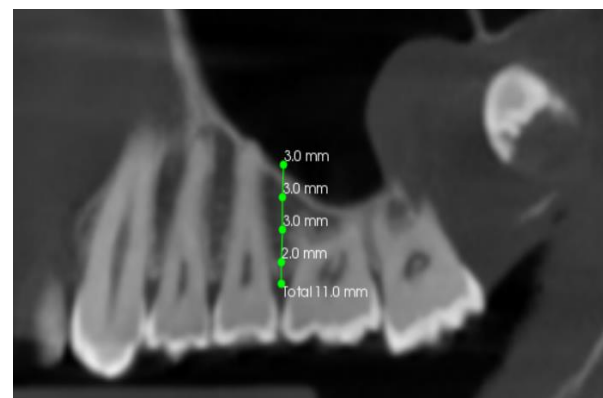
Sagittal view of the maxillary CBCT image. Sequential polyline between interdental space of the maxillary second premolar and the first molar
